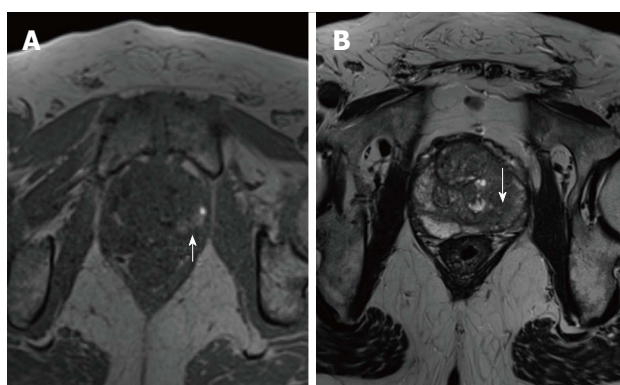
T1 (A) and T2-weighted images (B) of the midgland of the prostate. The left peripheral zone has a hyperintense area (white arrow, A) in T1-weighted image that correlates with a hypointensity (white arrow in B) in T2-weighted image, suggestive of bleeding in a patient with a recent transrectal ultrasound prostate biopsy.
